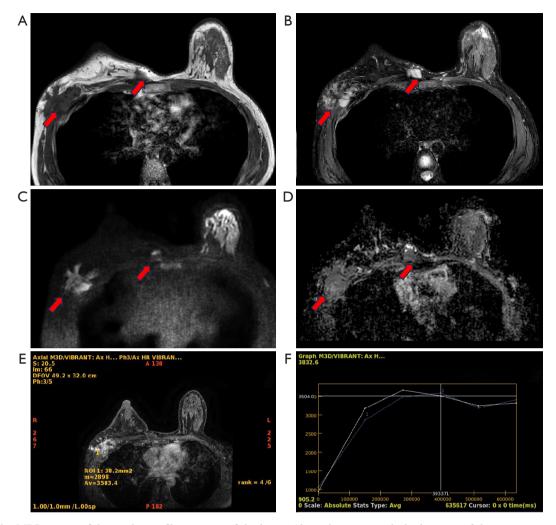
The MRI images of desmoid-type fibromatosis of the breast (the red arrows mark the location of the mass in case 1). (A) The masses exhibited low signal intensity on T1WI. (B) The masses displayed high signal intensity on T2WI. (C) The masses demonstrated high signal intensity on DWI. (D) The masses do not show significant reduction in signal intensity on ADC. (E) The larger mass exhibited heterogeneous enhancement on imaging. (F) The enhancement pattern demonstrated progressive enhancement followed by gradual fading in the larger mass (X axis: time; Y axis: enhancement value). MRI, magnetic resonance imaging; T1WI, T1-weighted imaging; T2WI, T2-weighted imaging; ADC, apparent diffusion coefficient.
